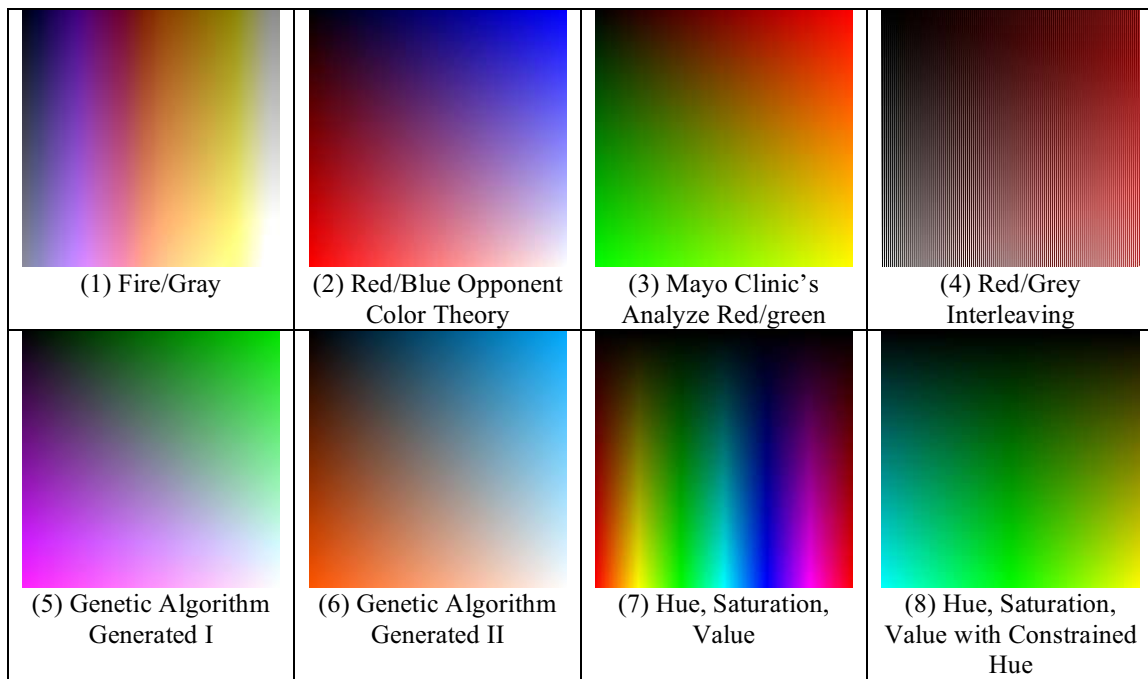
Color tables for the different fusion techniques investigated in the study. The vertical direction corresponds to the MRI intensity and the horizontal to the PET intensity. The origin is located in the upper left
